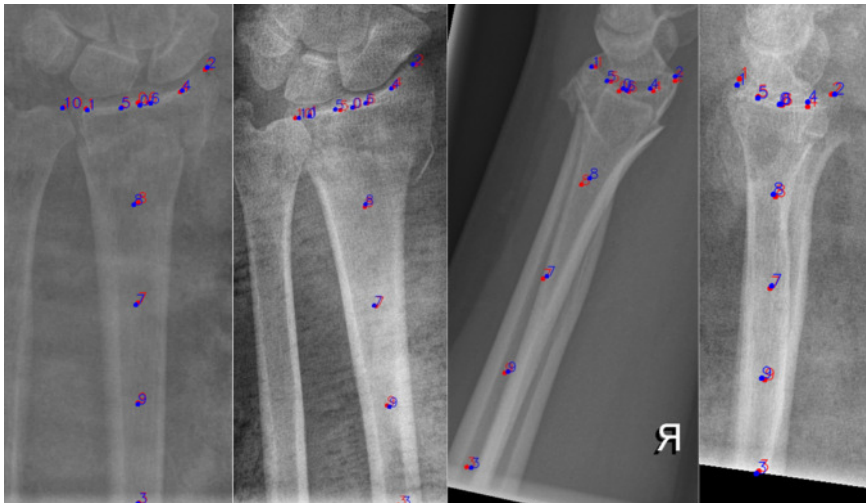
Visualization of landmark detection results on the testing set on postero-anterior view and lateral view, in trauma and post-reduction radiographs. The predicted landmarks (blue), and the corresponding manual landmarks (red) are overlaid to show accuracy.
